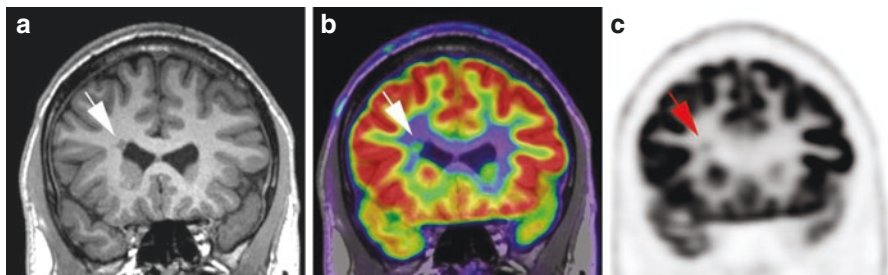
Subependymal cortical heterotopia. Subependymal nodule at the frontal horn of the left ventricle, with intensity similar to the normal cortex ((a) T1-weighted magnetization-prepared rapid gradient echo (MP RAGE)) (white arrow), appearing hypermetabolic as compared to the adjacent white matter in PET/MR fusion (b), and FDG-PET (c) (white and red arrows, respectively)
